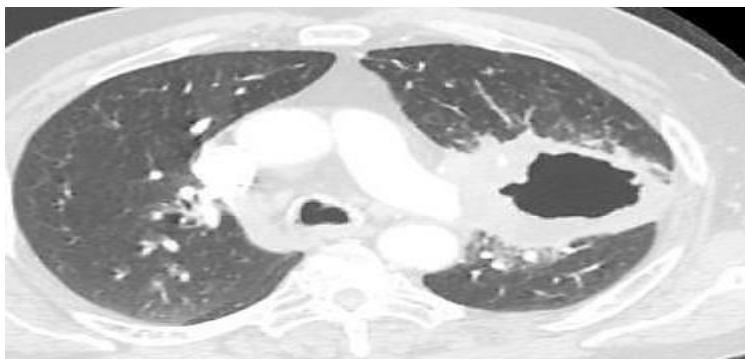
Malignant cavity. *Nin et al. Solitary lung cavities: CT findings in malignant and non-malignant disease. Clin Radiol 2016; 71:1132–6.*
